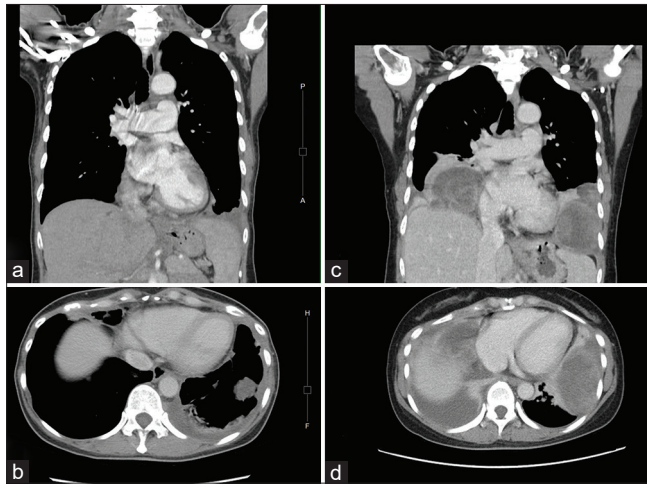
(a and b) Computed tomography (CT) scan at best response in April 2022. (c and d) CT scan showed progressive disease and increased pleural tumor size at 5 months after starting alectinib
